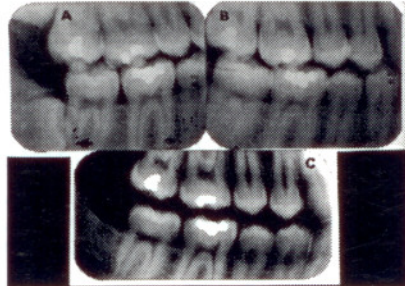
"Bite wing" radiographs of the right posterior teeth showing the morphology of the restorations in the molar teeth. Note that the wisdom teeth 18 and 48 are still present at this stage. The impacted 48 has caused external resorption of the 47 distal root (arrowed). A and B are antemortem and C postmortem radiographs.
